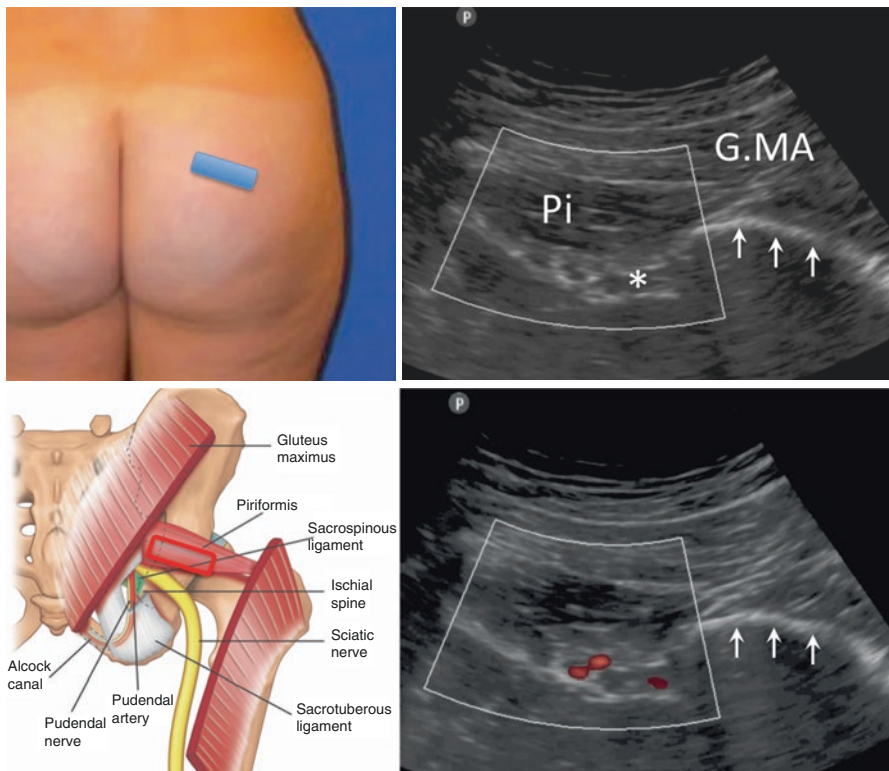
Position of the ultrasound probe over the greater sciatic notch and the pertinent anatomy and sonoanatomy. G MA, gluteus maximus; Pi, piriformis; *, the sciatic nerve; branch of inferior gluteal artery, red in color Doppler; the ischium is indicated by arrows. (Reprinted with permission from Philip Peng Educational Series)
